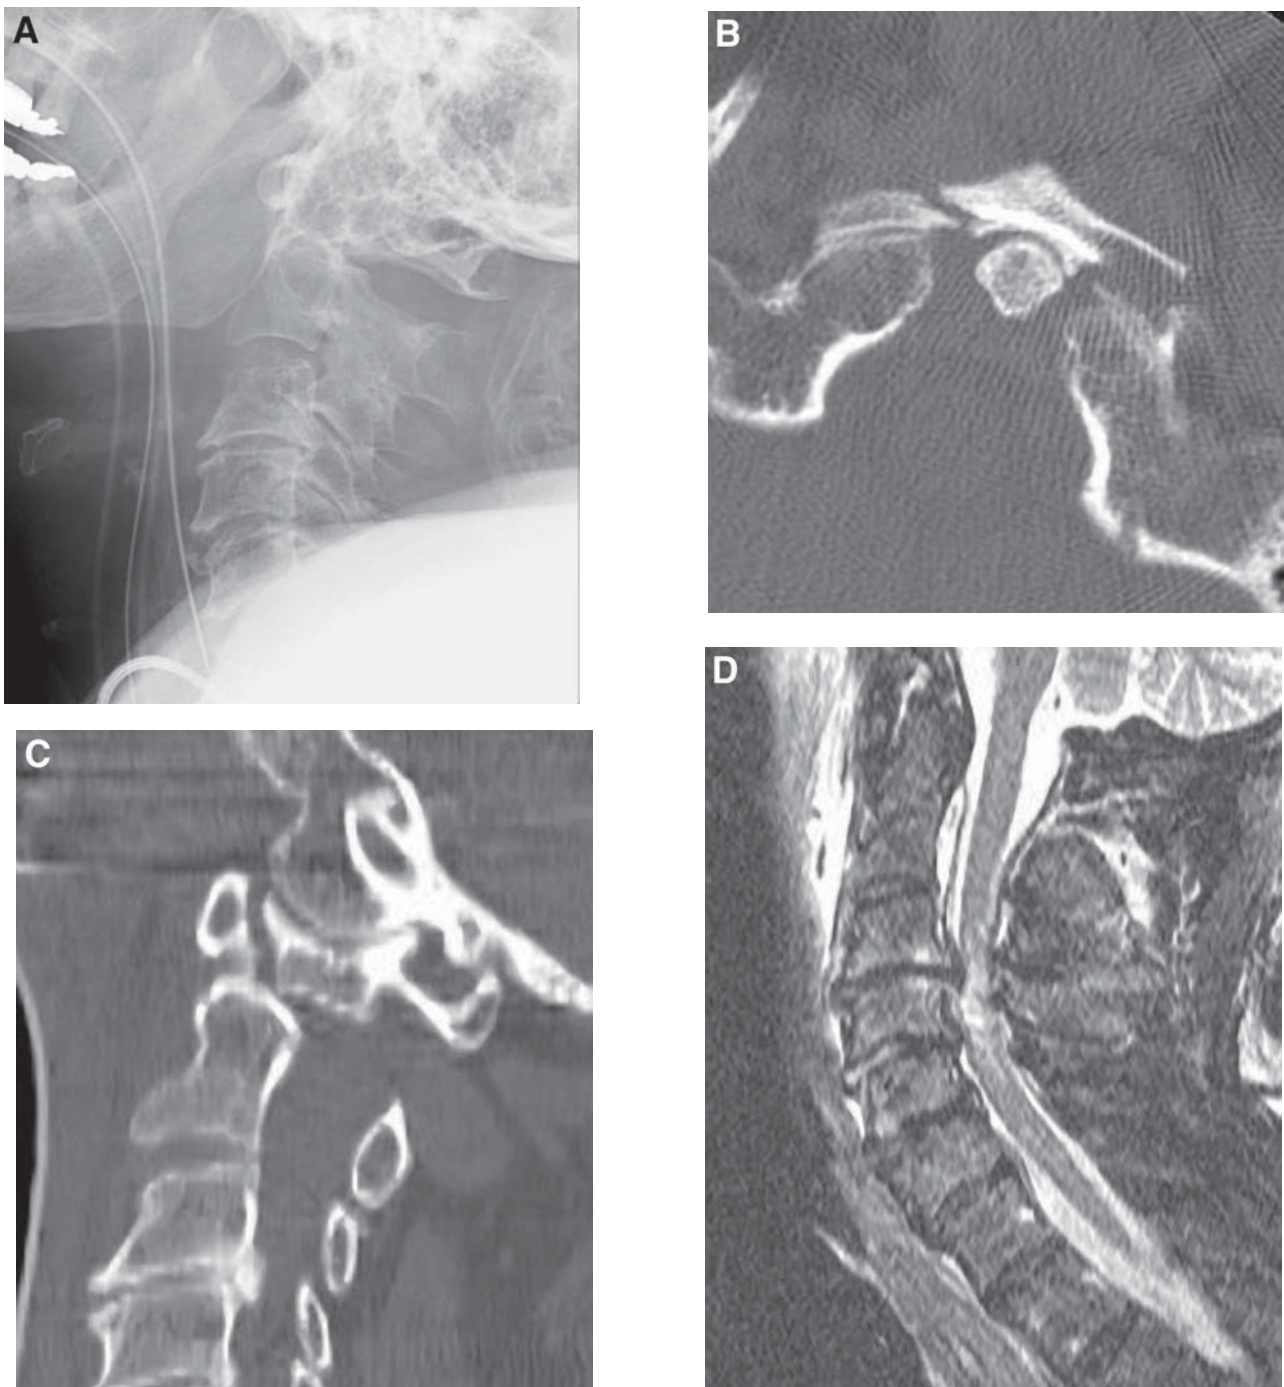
(A) Lateral radiograph was obtained following trauma in a patient with acute quadriplegia. The endotracheal tube precluded obtaining a satisfactory odontoid view. The lateral view was initially interpreted as showing no fracture. Axial CT (B) and sagittal CT reformation (C) demonstrate minimally displaced fractures of the anterior arch of C1, which extended into the C1 lateral mass bilaterally. (D) Sagittal STIR reveals spinal cord edema at the C3–4 level, which is not directly related to the fractures. The likely mechanism is a hyperextension injury in the setting of degenerative spinal stenosis. Note the dorsal osteophyte complex at C3–4 on the sagittal CT image. This example underscores the complementary nature of CT and MRI in the trauma setting.
